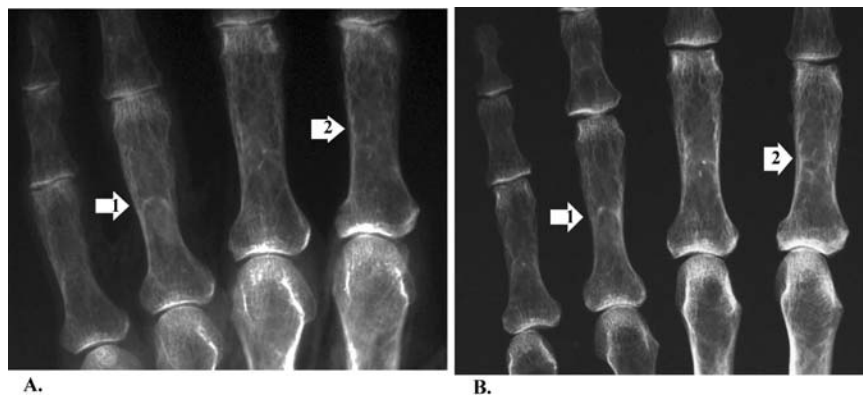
An example of a correct match between antemortem and postmortem, posterior-anterior hand radiographs. Figure 2A is the antemortem radiograph and Fig. 2B is the postmortem hand radiograph. The numbered arrows (1&2) refer to corresponding features between the two radiographs. In both cases, details of matching trabecular patterns are indicated.
